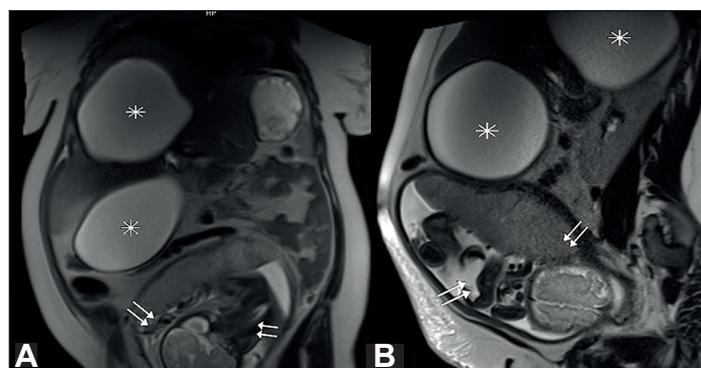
MRI of the abdomen T2-weighted (A) coronal and (B) sagittal images show hyperintense giant cysts (asterisk) in the liver that compress the uterus and fetus (arrows).
